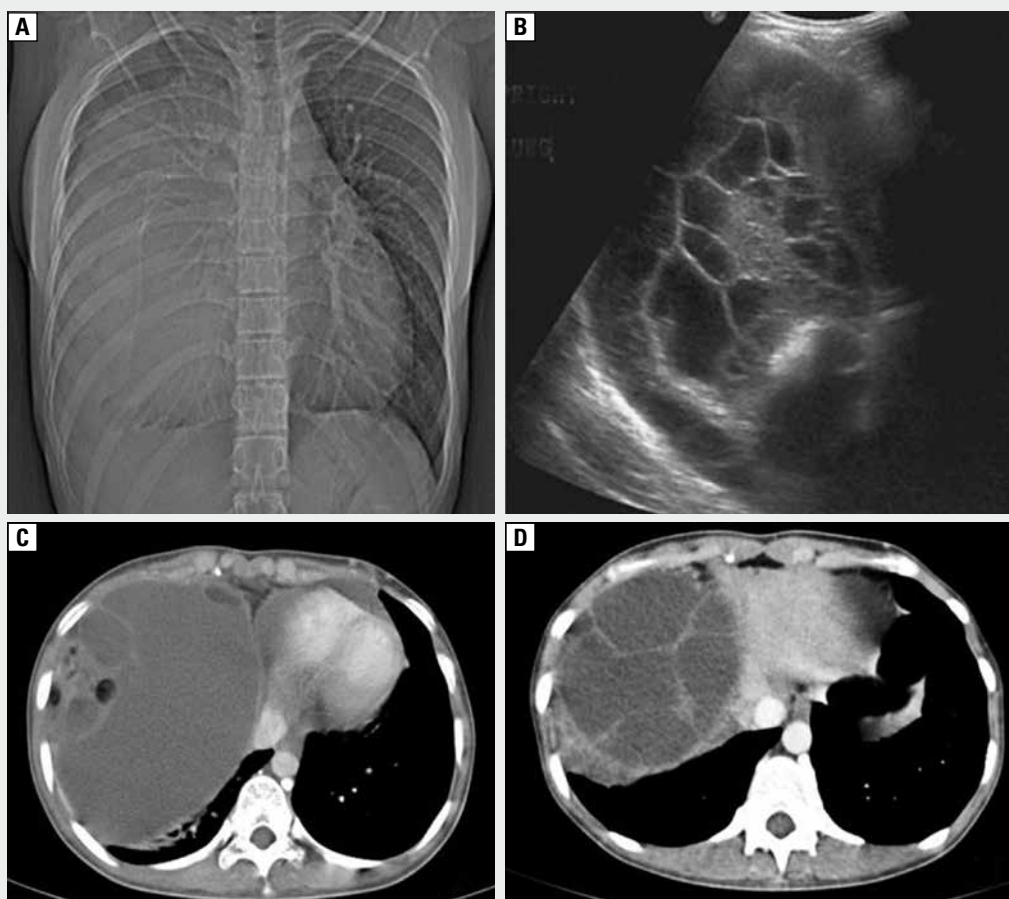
A. Chest X-ray showing homogenous opacity at the right side; B. USG of the chest showing effusion with multiple loculations; C. Chest CT showing large well-defined mass, which is low attenuating with focal areas of fat and calcification, areas of cystic degeneration; D. Anterior mediastinal cystic mass with solid enhancing septa
